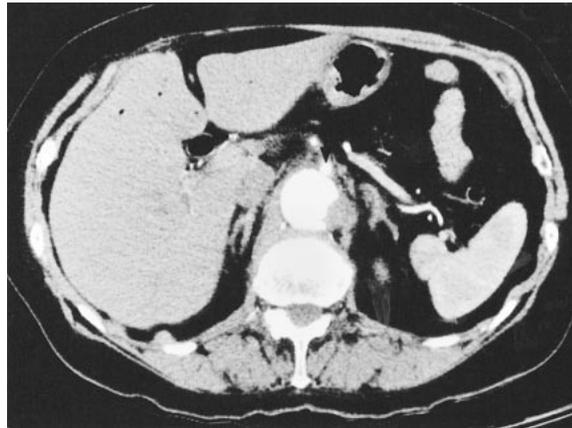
♦ Contrast computed tomography scan from the female patient showing the distal extent of the thoracoabdominal aneurysm on the left side; the celiac artery (arrow) is visible anteriorly.
